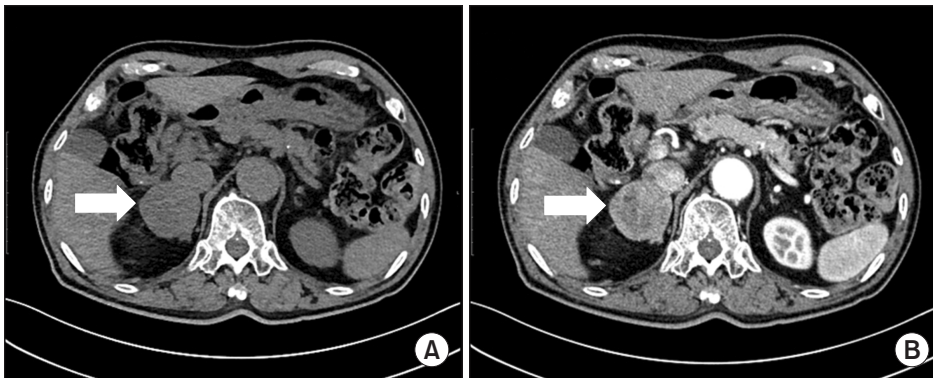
(A) Precontrast image of the adrenal CT presenting the right adrenal tumor (arrow). (B) Postcontrast image of adrenal CT presenting an irregular shape and heterogeneous enhancement (arrow) of the same right adrenal tumor.
